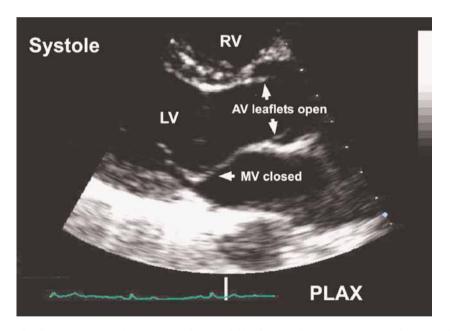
Parasternal long-axis view at end systole demonstrating the following cardiac structures: RV, right ventricle; LV, left ventricle; AV, aortic valve; MV, mitral valve.
